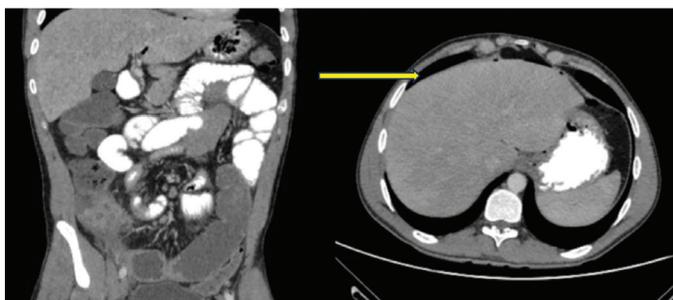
Perforation and free air in the abdomen due to Crohn's disease. Computed tomography image
